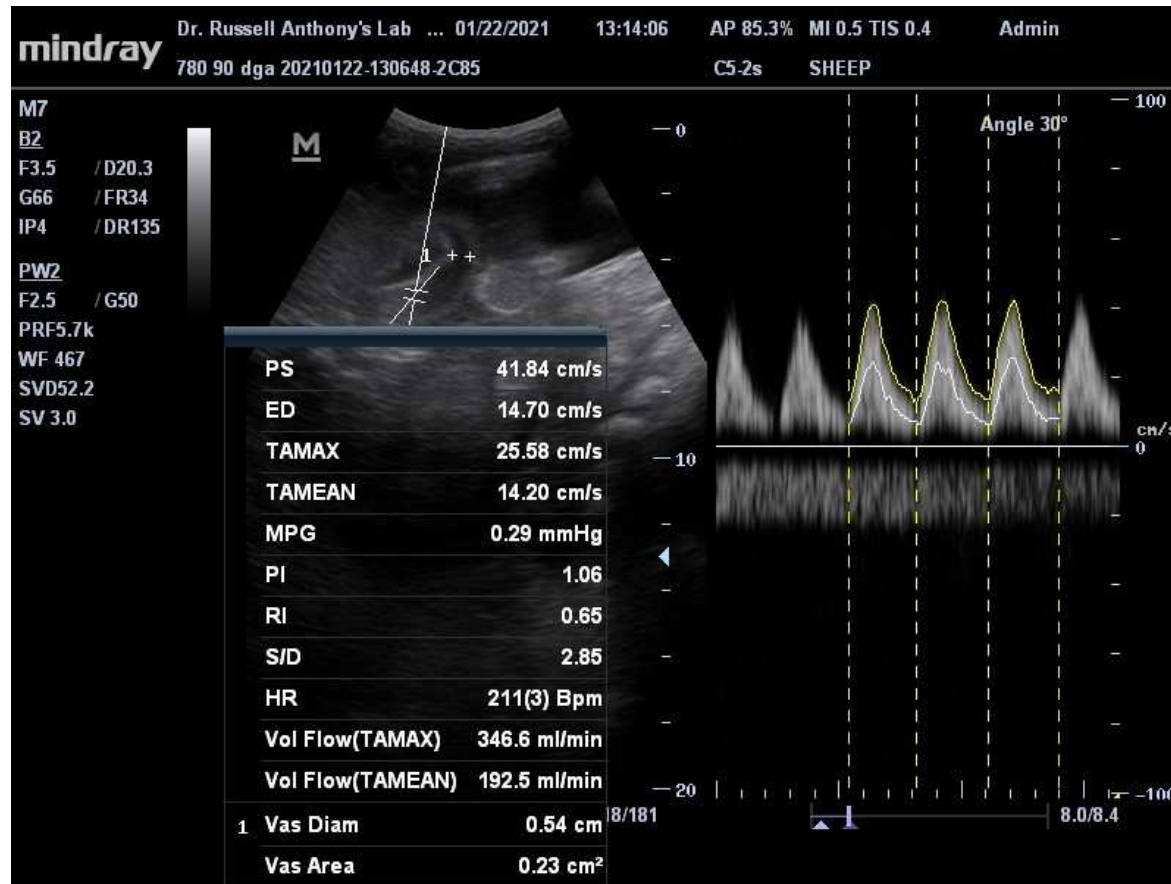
Doppler velocimetry measures the umbilical artery of a 90 dGA fetal lamb.
